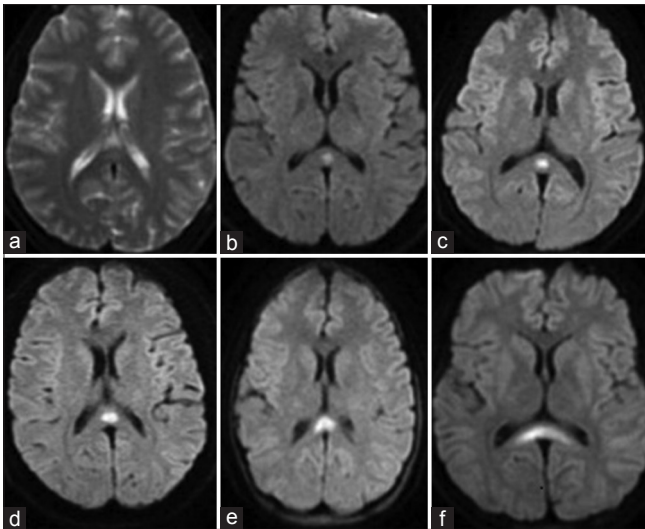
1.5 T Magnetic resonance imaging of the brain showing varying degrees of diffusion restriction in the splenium of corpus callosum. (a) Subtle diffusion restriction, (b) early dot sign, (c) classic dot sign, (d) expanding dot sign, (e) early boomerang sign, (f) classic boomerang sign
